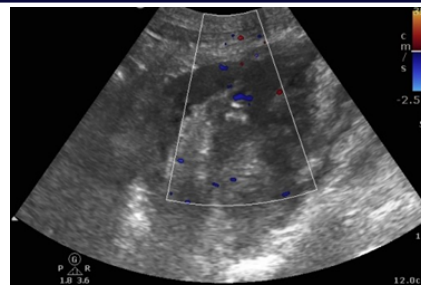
Doppler assessment after 24 hours post thrombin injection into the aneurysms shows partial recanalization of the sac.
